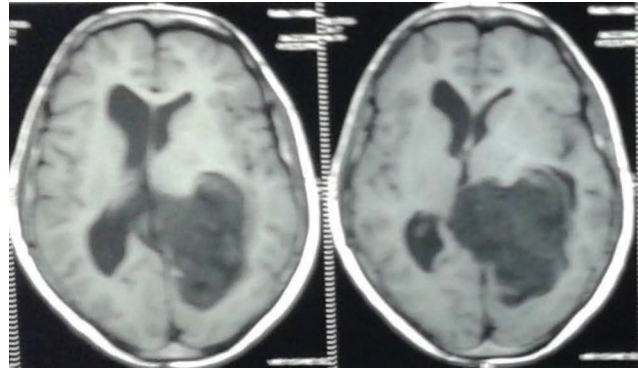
Axial CT scan images showing large left lateral ventricular epidermoid cyst.
